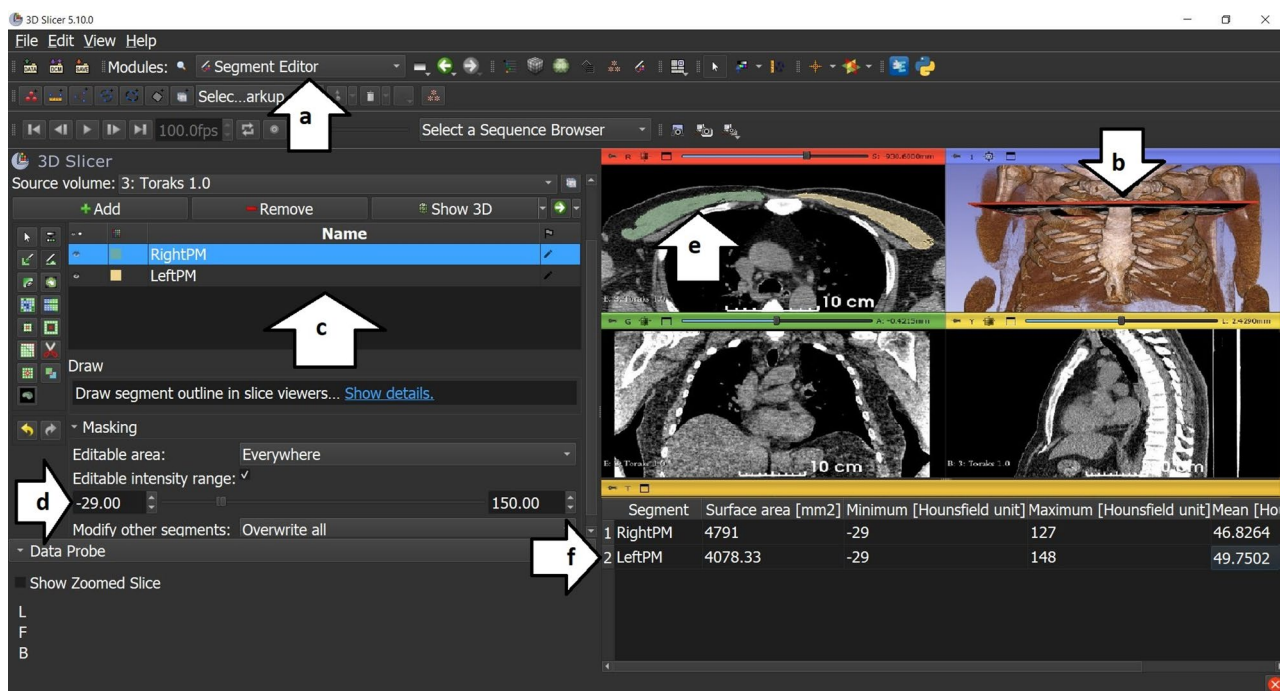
Measurement of the cross-sectional area and mean density of the pectoralis major muscle. Segmentation of the pectoralis major muscles on axial CT images. a The Segment Editor module was selected. b The axial slice at the level of the sternal angle (manubriosternal junction) was identified. c Two separate segments were created for the right and left pectoralis major muscles. d A threshold of -29 to $+150$ Hounsfield units (HU) was applied to define muscle tissue. e Manual delineation of the pectoralis major muscle borders was performed. f Muscle cross-sectional area and mean density were calculated from the segmented regions. The right pectoralis major muscle is shown in green and the left in yellow
